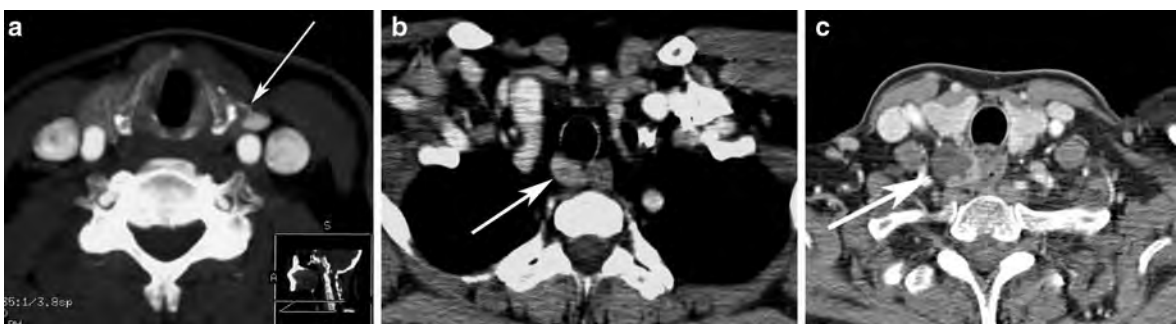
Axial contrast-enhanced CT images demonstrating an enlarged parathyroid gland with a vascular pedicle (arrow) (a) and two examples of enlarged retrotracheal ectopic parathyroid glands (b, c) (arrows)
